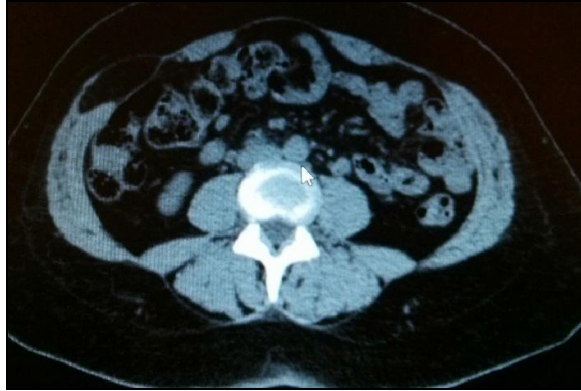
Coronal CT scan abdomen
